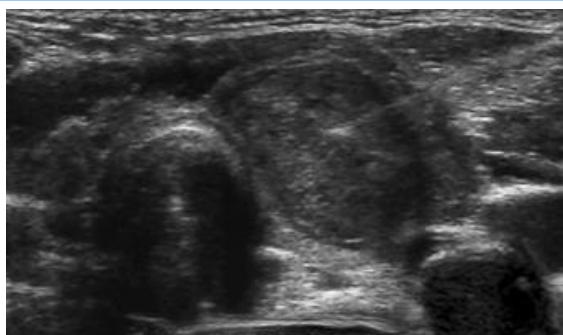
Fine needle aspiration guided by sonography of a hypoechoic nodule proved as papillary thyroid carcinoma.
